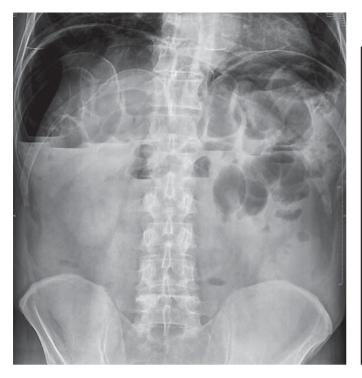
Standing abdominal radiograph showing pneumoperitoneum, intestinal distension, and air-fluid levels.
